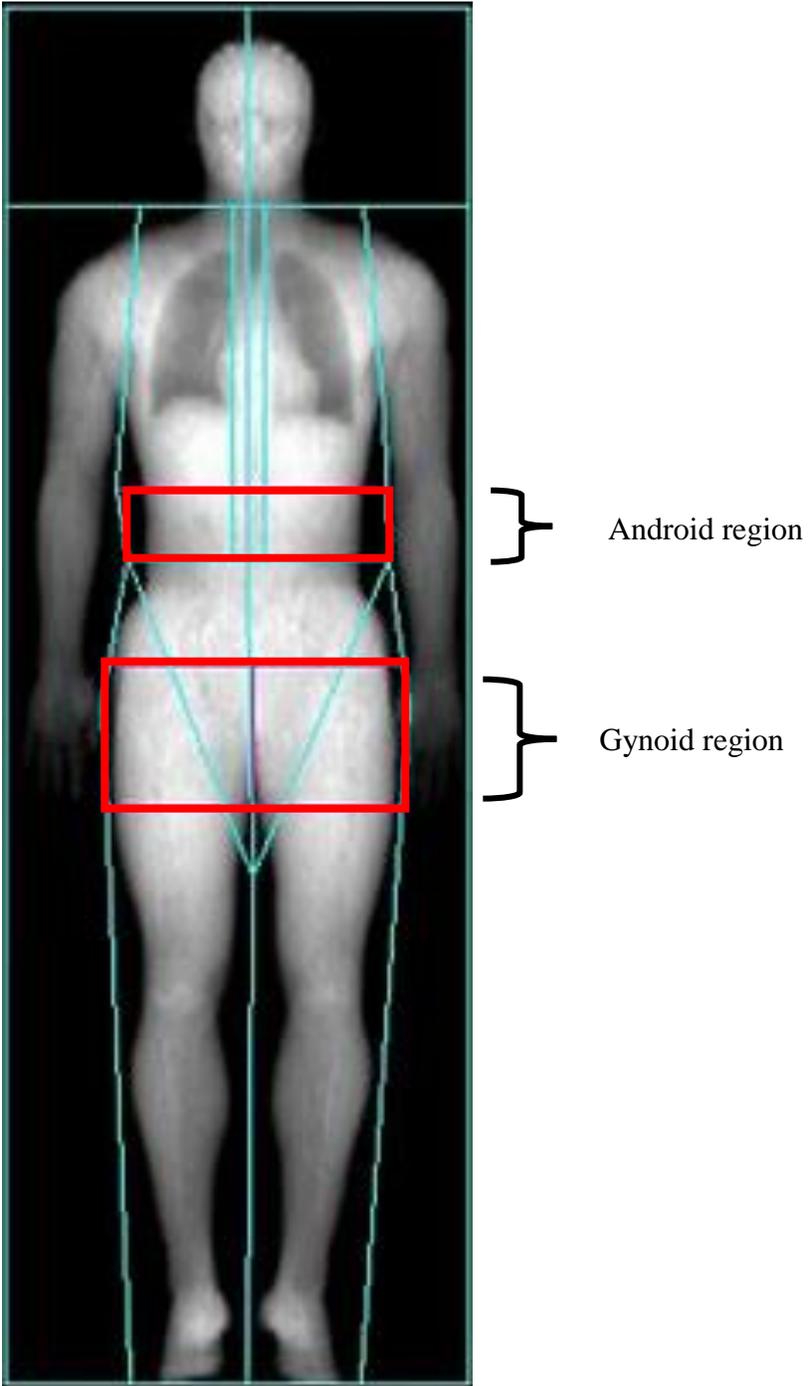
1: The android and gynoid regions of interest determined by dual energy X-ray absorptiometry
